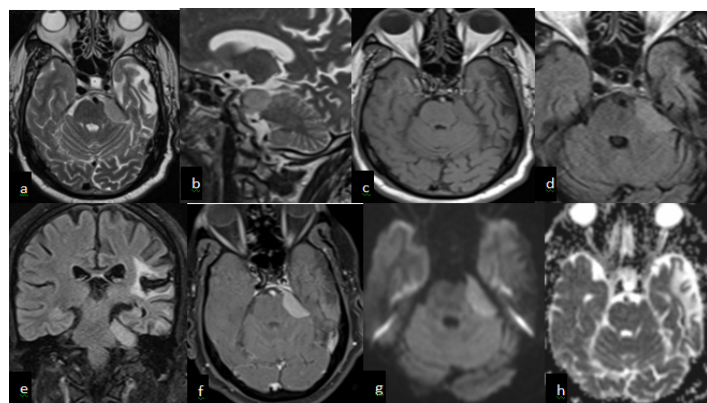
Left CPA meningioma in a patient present with dizziness and left sensorineural hearing loss. (a,b) Axial and sagittal T2-weighted image demonstrates dural based solid mass lesion in left cerebellopontine angle region (c) the lesion appears iso to hypointense on T1-weighted imaging and (d,e) relatively hyperintense on axial and coronal FLAIR images. (f) Axial post-contrast T1-weighted image shows intense homogeneous contrast enhancement of the mass with a broad base dural attachment. The lesion shows minimal mass effect over pons. (g) Axial diffusion-weighted image and the (h) corresponding apparent diffusion coefficient (ADC) map show associated restricted diffusion
